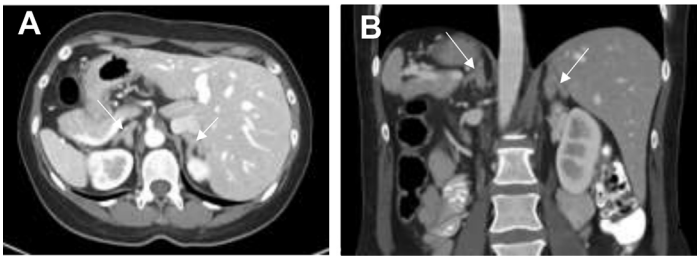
A 43-year-old woman with situs inversus totalis and a history of Cushing disease due to a pituitary macroadenoma resected 7 years previously was referred to the endocrinology clinic for recurrent signs and symptoms of hypercortisolism. Axial contrast-enhanced CT (A) and coronal reformatted images of contrast-enhanced CT (B) show bilateral diffuse thickening of the adrenal
